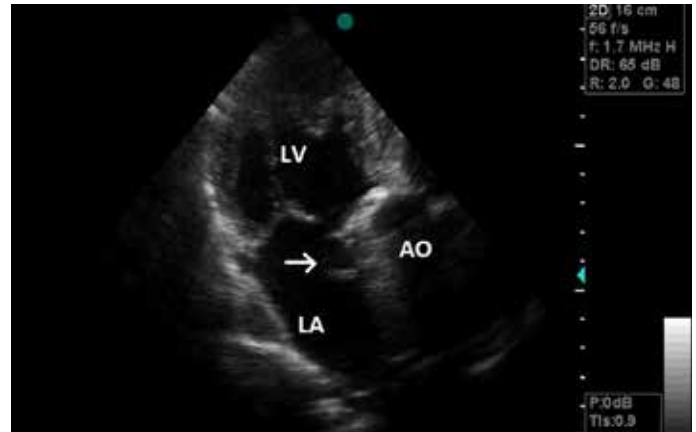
Transthoracic echocardiography views showing echolucent area adjacent to the aortic valve (arrow)
